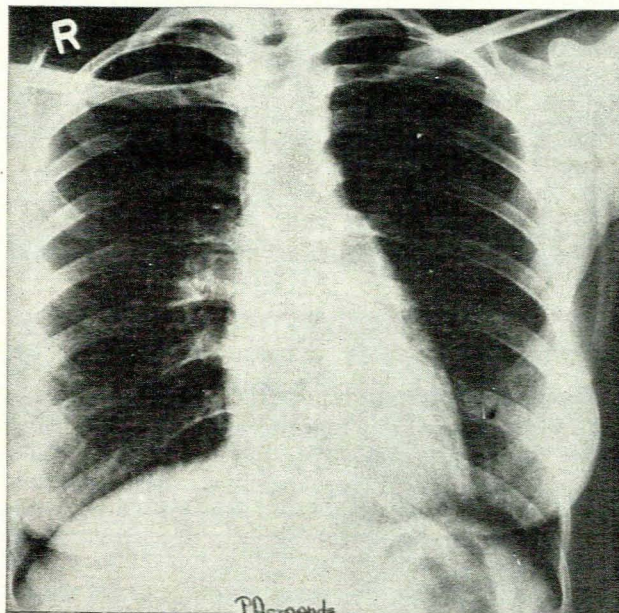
Chest radiograph showing the 'mitralized' heart and normal lung fields.
